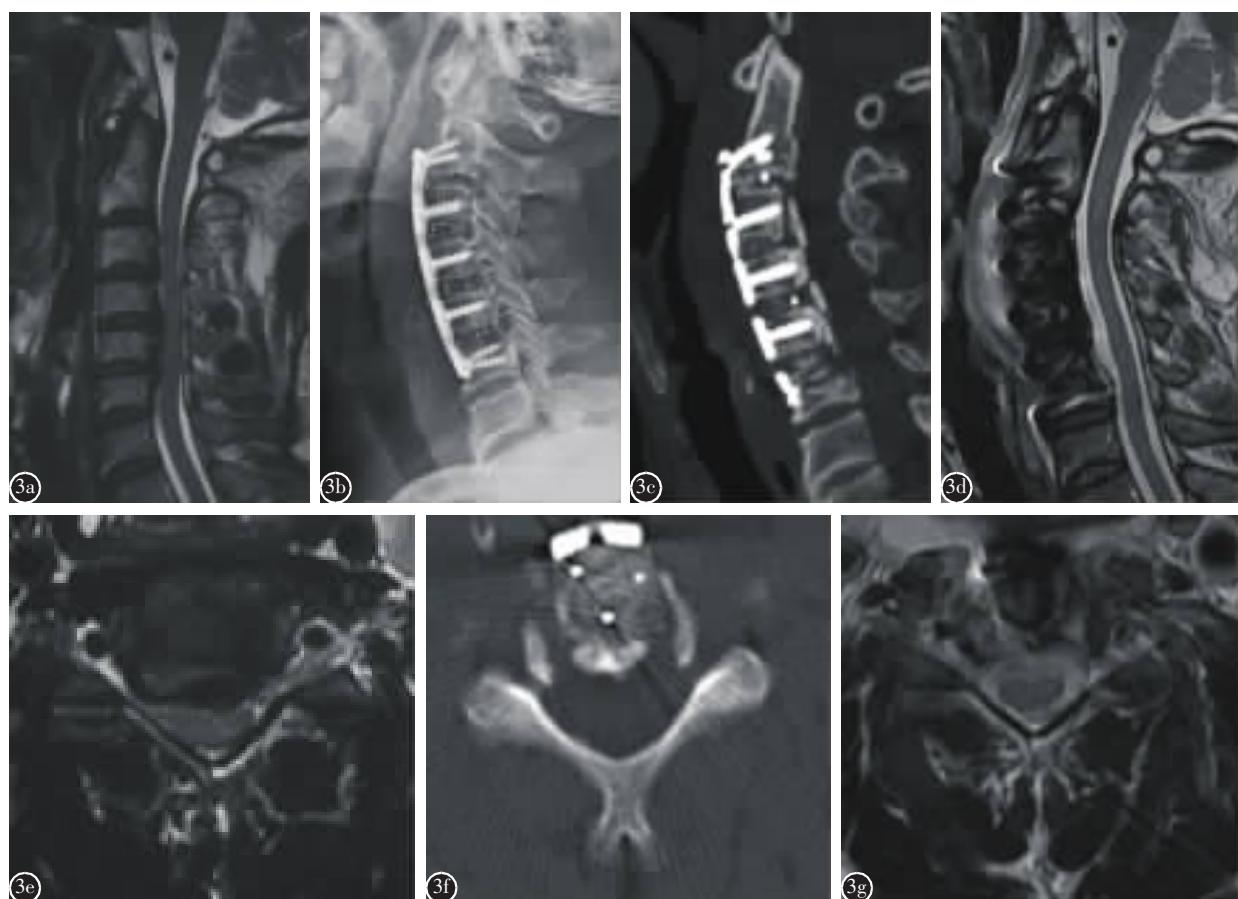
ACAF 病例术前及术后影像 a 术前 MRI 矢状面 b 术后 X 线侧位, 示提拉 C3–C5 c 术后 CT 矢状面 d 术后 MRI 矢状面 e 术前 C5 节段 MRI 横断面 f 术后 C5 节段 CT 横断面, 示椎管空间在前方扩大 g 术后 C5 节段 MRI 横断面, 示脊髓位置居中, 两侧神经根走行对称
